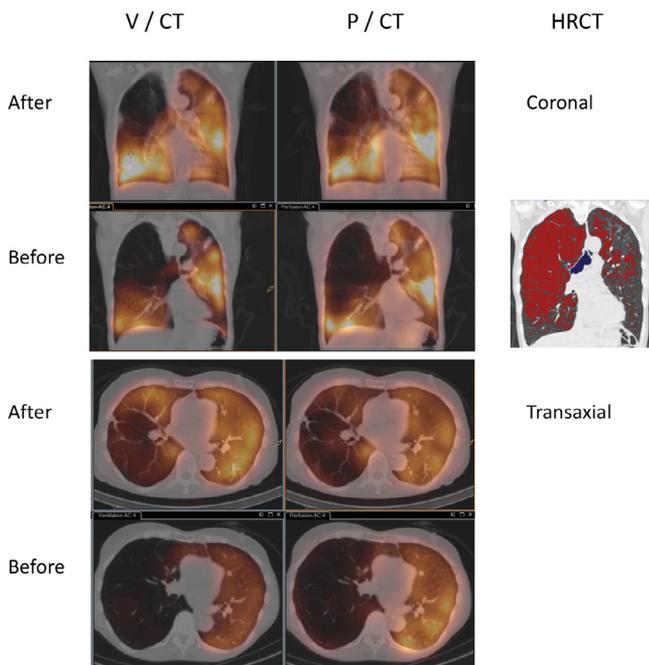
V/Q SPECT/CT in a patient with severe COPD with emphysema before and after lung volume reduction surgery. Severe reduction of ventilation and perfusion in the upper part of right lung corresponding to centrilobular emphysema seen on HRCT. After lung volume reduction surgery of the right upper lobe, ventilation, and perfusion improves in the right lung which also is less hyperinflated. Left: fused ventilation ($^{81\text{m}}\text{Kr}$)/CT; mid: fused perfusion/CT. Right: HRCT with red marking of emphysema (47% emphysema; 62% in right and 20% in left lung). COPD, chronic obstructive pulmonary disease; HRCT, High-resolution CT; V/Q, ventilation-perfusion.
